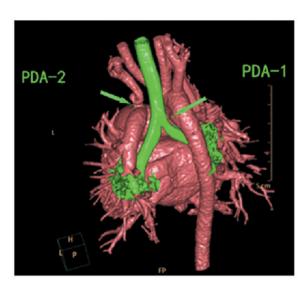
Volume-rendered computed tomography image clearly showing the double. PDA, patent ductus arteriosus.
